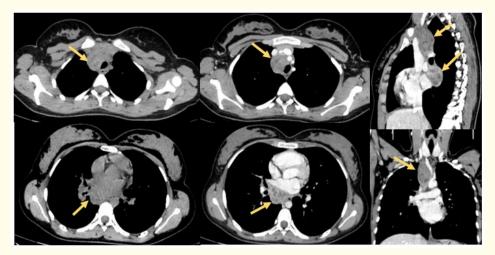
Chest CT (axial, sagittal and coronal view): Two lesions in the posterior medistinum (Arrow) showing spontaneous low density, slightly enhanced after administration of contrast with central cystic components.
